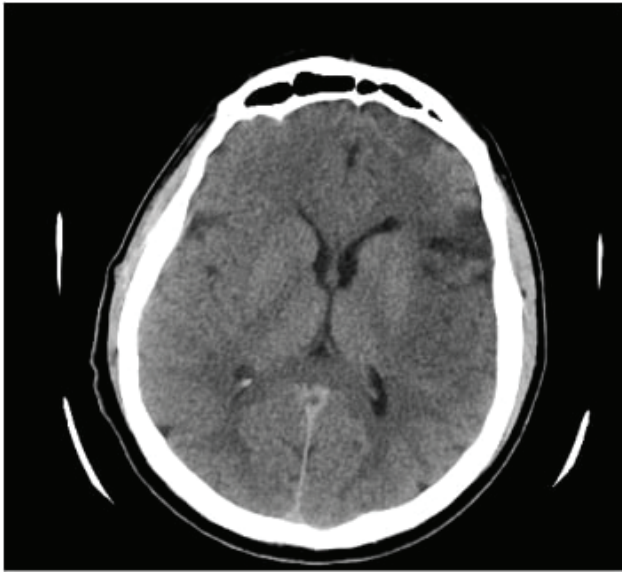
Brain CT shows a moderately hypoattenuating lesion in the left frontal, insular, and parietal lobes, and an acute ischemic stroke in the middle cerebral artery territory.
